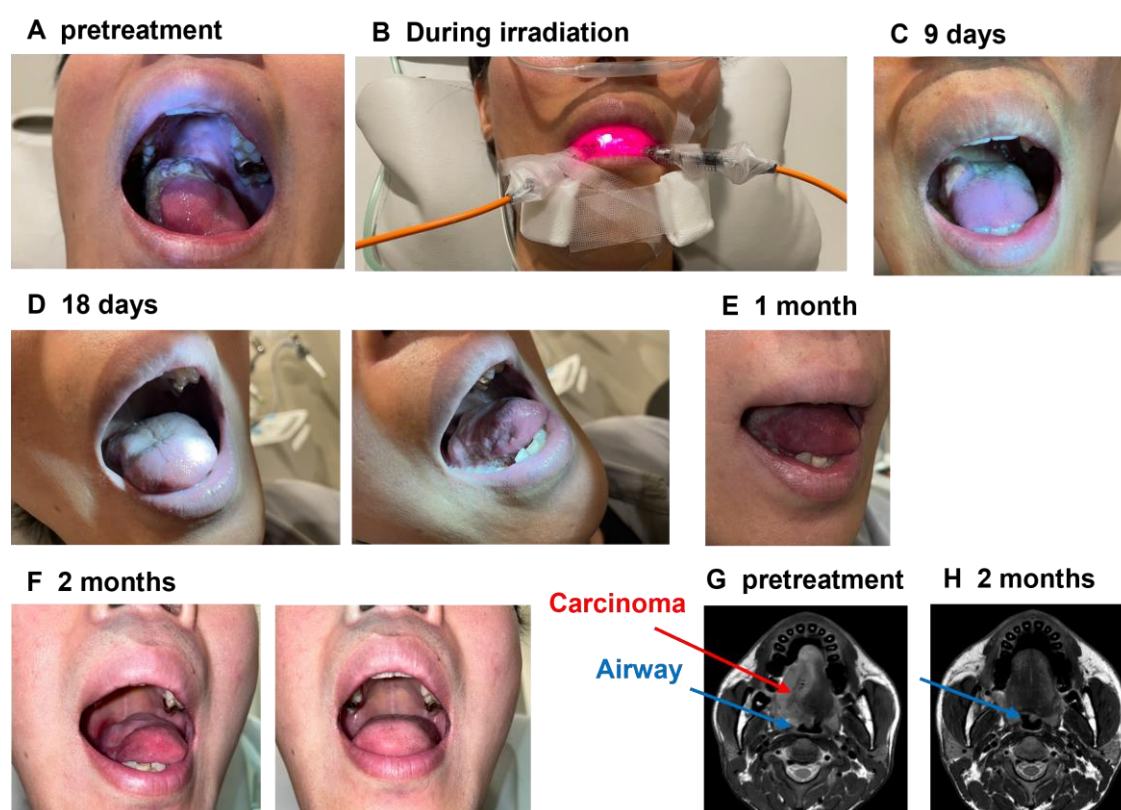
(A) Images showing the patient with tongue cancer prior to photodynamic therapy (PDT) using IR-783. (B) The patient undergoing infrared light irradiation. A large tumor is visible on the right middle part of the tongue. (C) Image obtained 9 days following the initial intervention showing a reduction in tumor size. (D) Image obtained 18 days following the initial intervention showing that the tumor in the upper portion of the tongue is no longer discernible, and only an ulcerative lesion in the right side of the tongue is visible. (E, F) Images obtained 1 and 2 months following the initial intervention, respectively. No lesions are identified, and there is no observable tendency for recurrence. (G) Magnetic resonance imaging (MRI) of the patient prior to photodynamic therapy using IR-783. (H) MRI of the patient 2 months following the initial intervention. The red line denotes the tumor tissue, while the blue line represents the airway. After 2 months, the tumor is no longer discernible on the MRI, and the stenotic airway has recovered.
